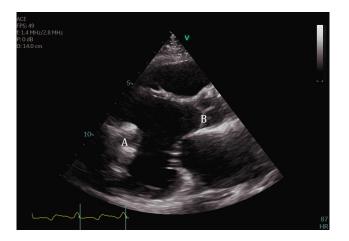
Transthoracic echocardiogram PLAX image demonstrating inflow cannula at LV apex (A) and AV systolic closure (B).
